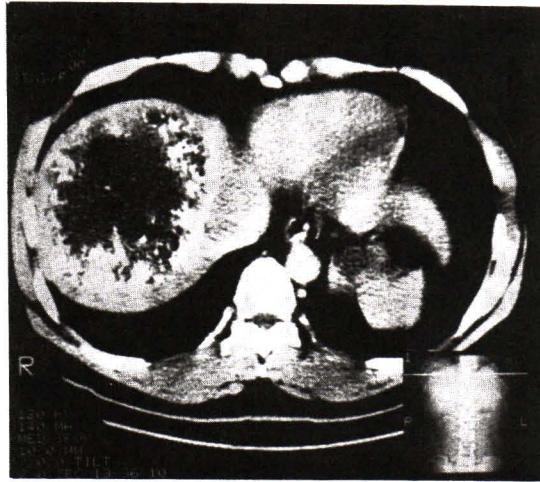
Lipiodol CT Scan of a tumor metastasized from CA colon shows peripheral accumulation of lipiodol with center defect.
